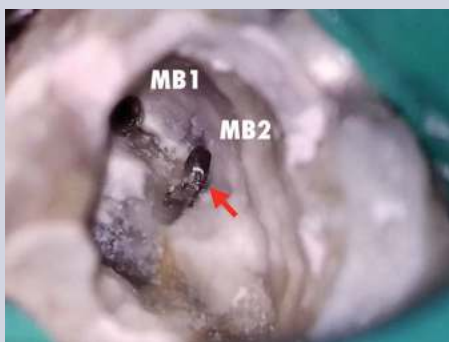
Separated instrument in second mesio-buccal canal of left maxillary first molar (arrow). Situation after uncovering of fragment with ultrasonic tips and debris removal.
